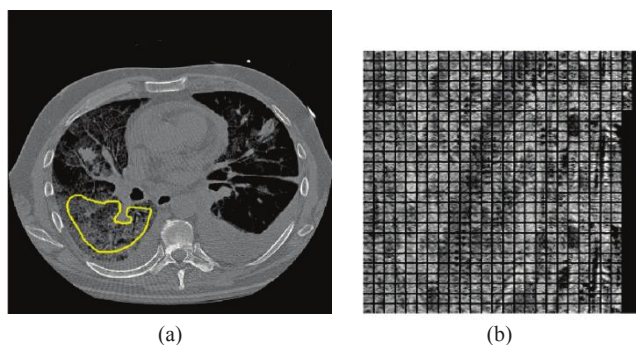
(a) A sample of a HRCT image slice with AROI (yellow). (b) Extracted patches that are completely enclosed in the AROI.
